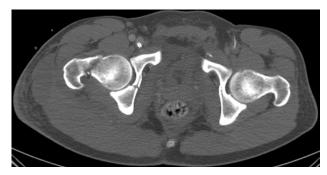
Pelvis CT. Displaced right femoral neck fracture and acetabular fracture are evident.
